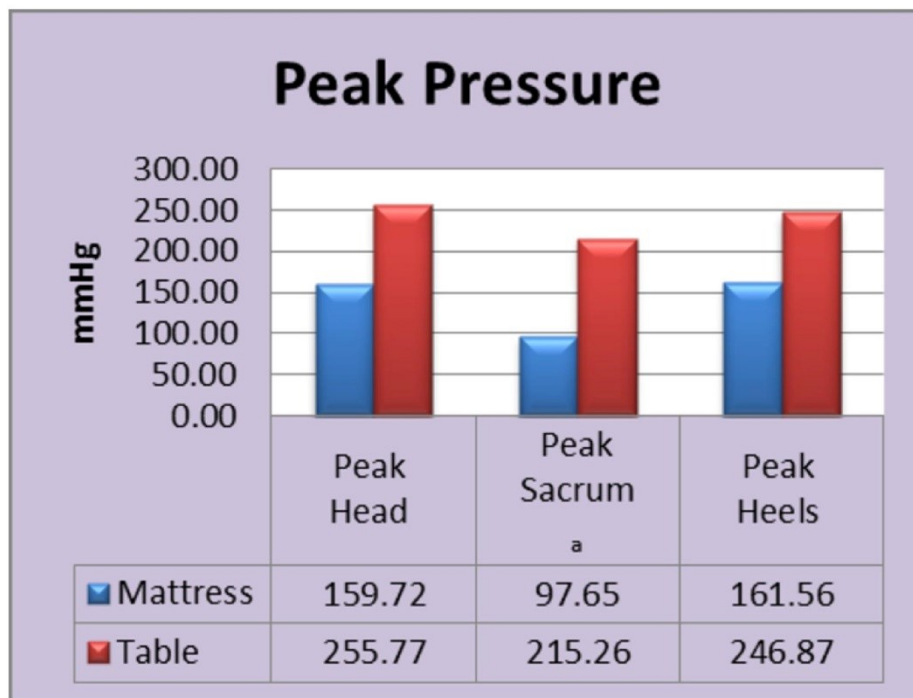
Graph comparing peak pressure in mmHg for each of the jeopardy areas for both the mattress and the x-ray table. Inc standard deviation. a Mean peak of the 3x3 area.
